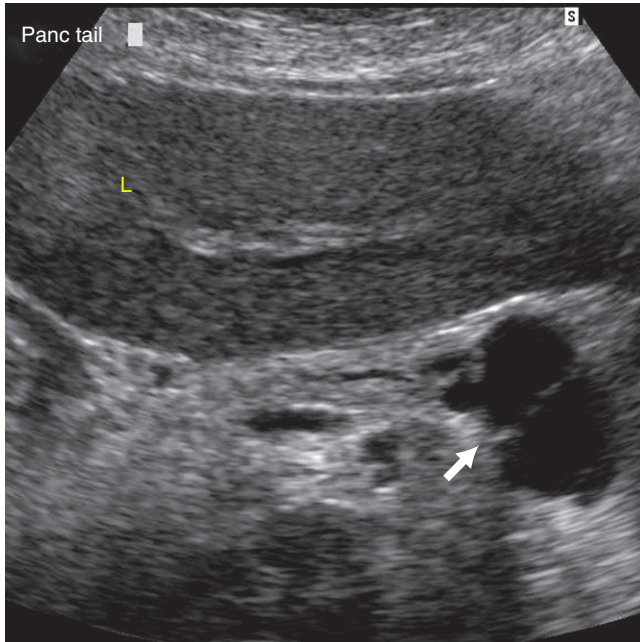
Transverse sonogram through liver (L) showing a cystic mass in the body/tail of pancreas (arrow).
